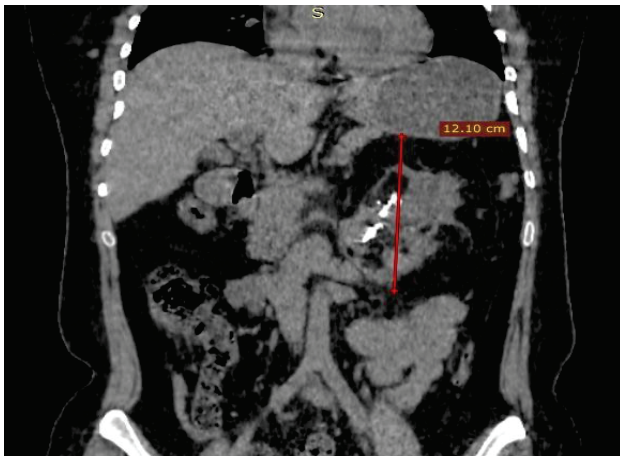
Non-contrast coronal Computed tomography (CT) image shows large well marginated oval mixed density mass in left upper abdomen, below stomach. Areas of fluid density, fat and globular calcifications seen in the lesion.
